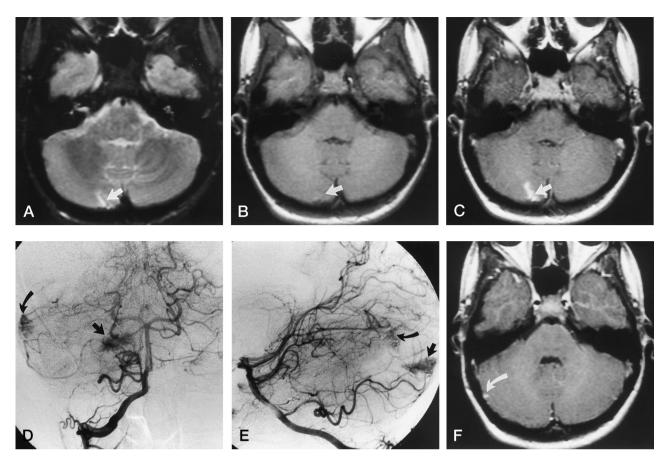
Axial T2-weighted (2000/80/1) (*A*), axial T1-weighted (500/20/1) (*B*), and axial contrast-enhanced T1-weighted (500/20/1) (*C*) MR images show an enhancing signal abnormality in the superior semilunar lobule of the right cerebellar hemisphere that was interpreted as an indeterminate vascular malformation (*arrows*).
